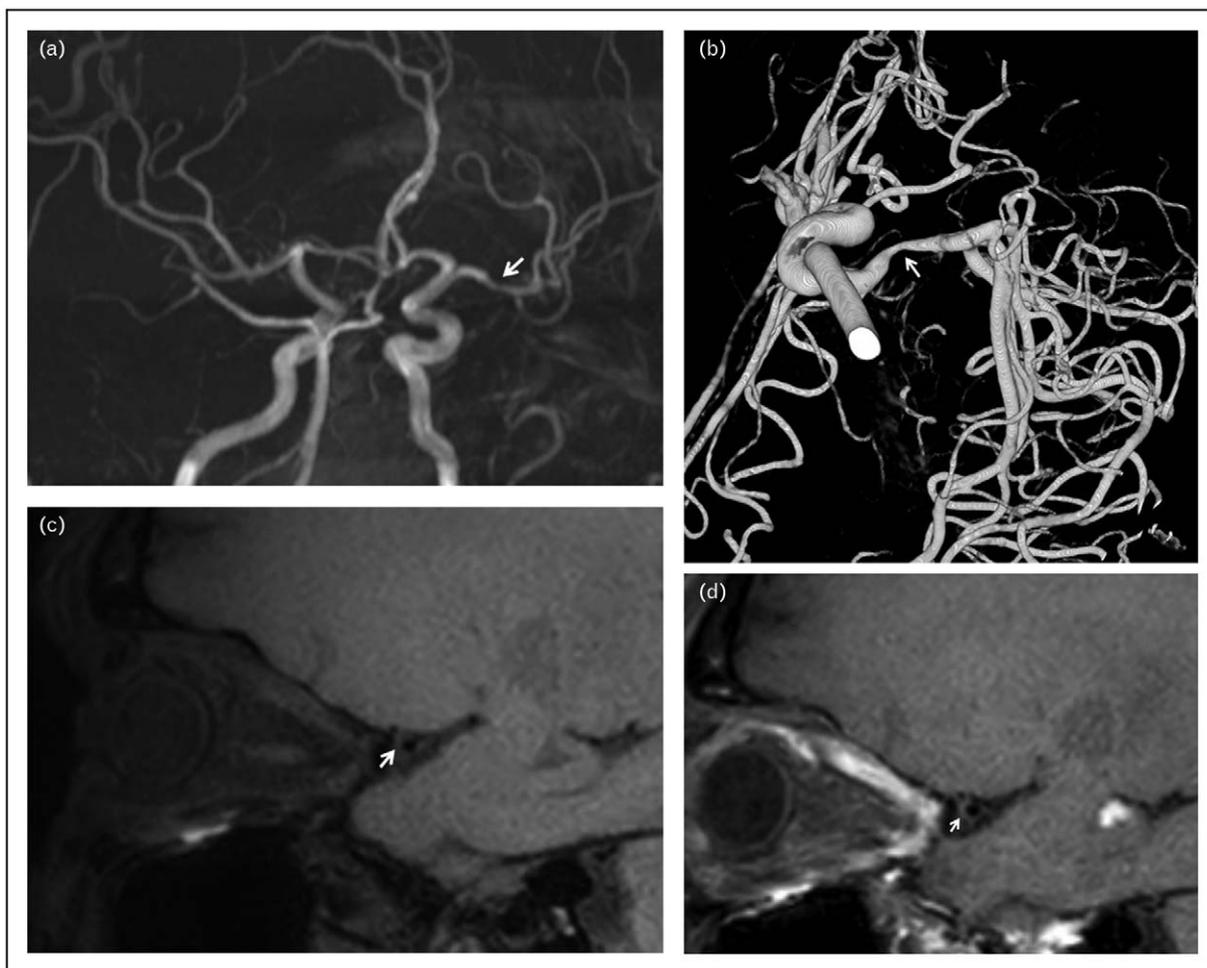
Central nervous system vasculitis. (a) A 53-year-old male patient presented with features suggestive of a transient ischemic attack. Time-of-flight magnetic resonance angiography and (b) three-dimensional digital subtraction angiography were performed and these demonstrated stenosis of the left middle cerebral artery M1 segment. (c) Pre and (d) postgadolinium images of vessel wall MRI show luminal narrowing and eccentric enhancement.
